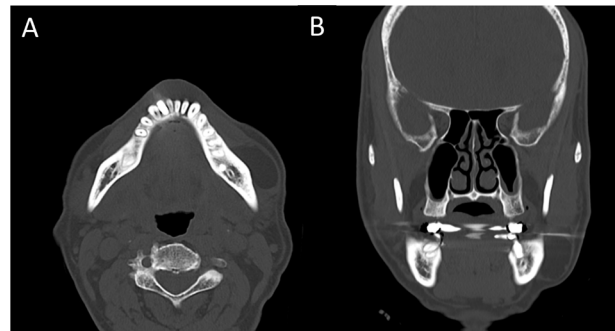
Preoperative computed tomography (CT) scans. (A) Axial view shows a well-demarcated, fat-density mass abutting the buccal cortex. (B) Coronal view confirms the parosteal location of the lesion, showing close contact with the underlying bone without cortical invasion or internal ossification.
